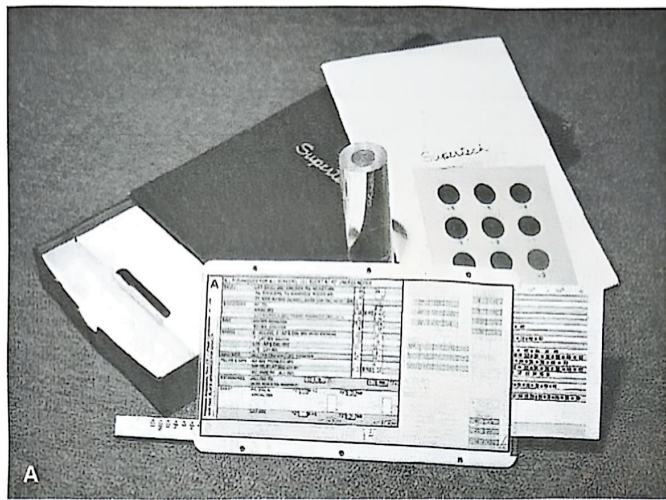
(A) Supertech calculator kit. (B) X-ray caliper for measurement of body parts.
